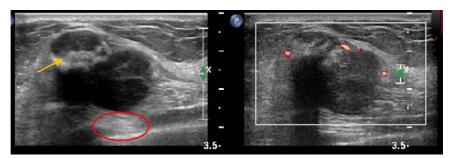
Ultrasound imaging demonstrates a circumscribed irregular mass with rim vascularity at the area of palpable concern. The internal echotexture is heterogeneous. The echogenic area (arrow) corresponds to the coarse calcification on mammogram. The noncalcified component shows posterior acoustic enhancement (circle).
